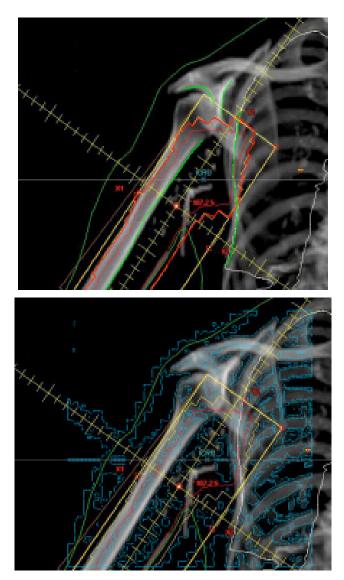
The top image shows a digitally reconstructed radiograph (DRR) from the CT image. The yellow box marks the extent of the radiation field. The central image shows the manual bony contours added in green. The lower image shows the contours painted by the Java application.
